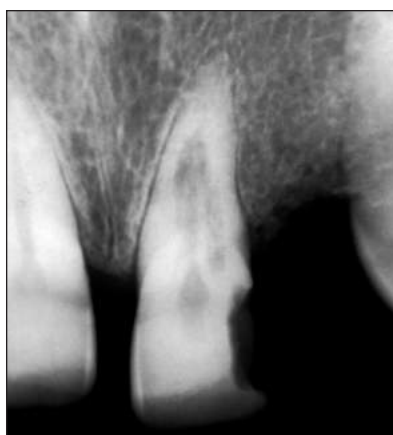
Radiograph of a maxillary central incisor with an extracanal invasive resorption lesion.
